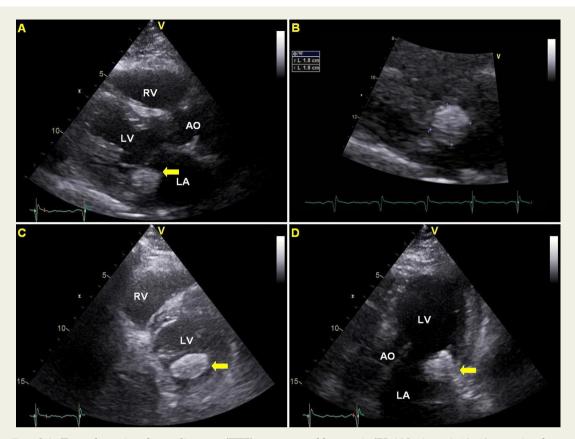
Panel A. Transthoracic echocardiogram (TTE), parasternal long axis (PLAX) view. A 18x18 mm circular mass with peripheral calcification and internal echolucent niches, originating from the posterior mitral annulus can be detected in this view. This corresponds to caseous calcification of mitral annulus (CCMA) (yellow arrow).
